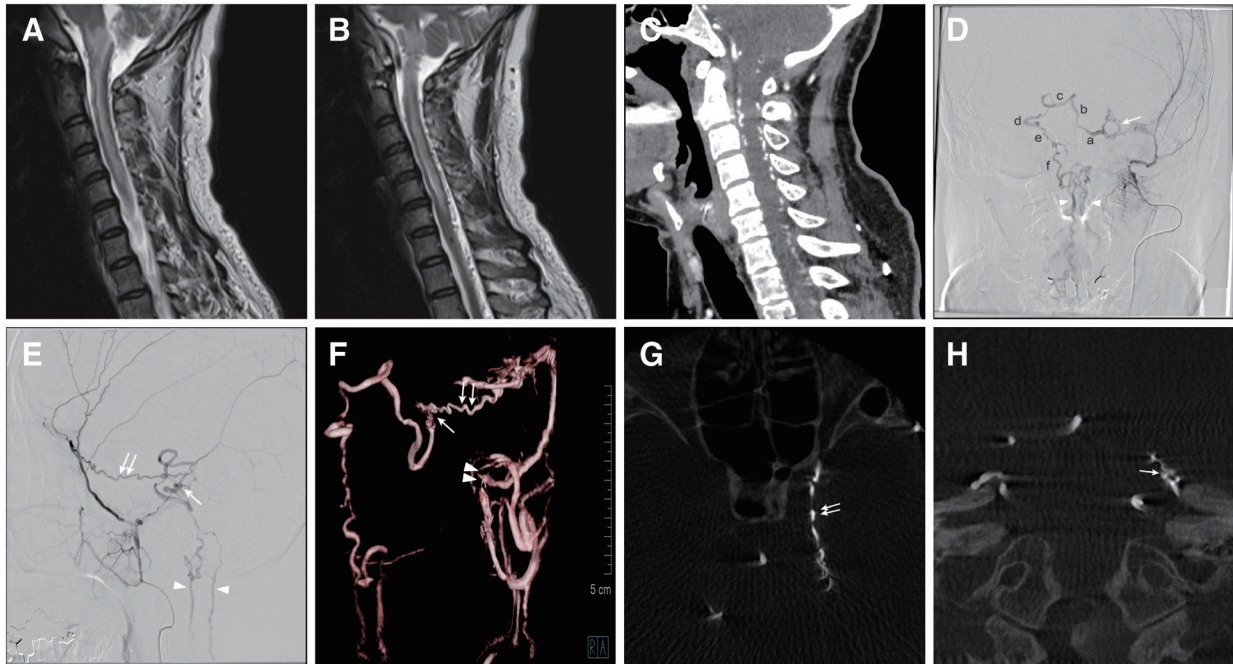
(A, B) Sagittal sections of MRI (two consecutive slices) showing the T2-hyperintensity and swelling in the brainstem and spinal cord from the medulla oblongata to vertebral level C6 with perimedullary vascular flow voids. (C) The sagittal section of CTA more clearly shows the tortuous and dilated vessels around the cervical spine. (D, E) Superselective angiograms of the left MMA. Anterior-posterior view (D) and lateral view (E). A single feeder from a sphenoid branch of the left MMA connects with the marginal tentorial artery (double white arrows) and runs toward the fistula point (single white arrow) on the top of the left petrous ridge, draining into a left petrosal vein. A drainer (a left petrosal vein) connects to a left transverse pontine vein (a), a median anterior pontomesencephalic vein (b), a right transverse pontine vein (c), a right petrosal vein (d), a right lateral pontine vein (e), and a right lateral medullary (f). These abnormal venous drainages finally connect to anterior and posterior spinal veins (white arrowheads). (F–H) The oblique view of 3DRA of the left MMA and its source images (axial and coronal sections). These images clearly show the MMA feeder connecting with a marginal tentorial artery (double arrows) that runs toward the shunt point (single arrow) on the top of the left petrous ridge. Double arrowheads indicate the foramen spinosum. MMA, middle meningeal artery; 3DRA, three-dimensional rotational angiography
